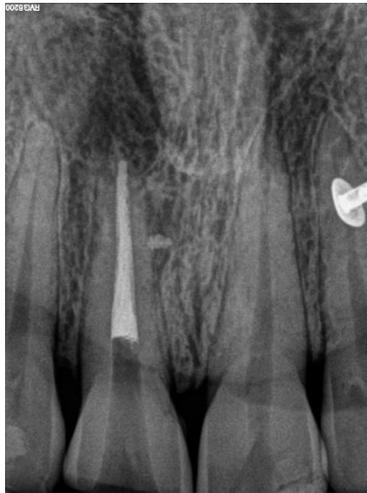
immediate post obturation radiograph with gutta percha removed 2mm below CEJ
